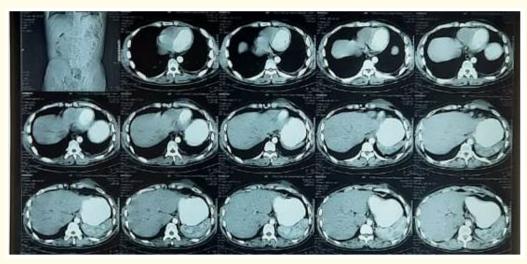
CT Chest showing cystic lesion with fluid content in the anterior aspect of right chest wall.
